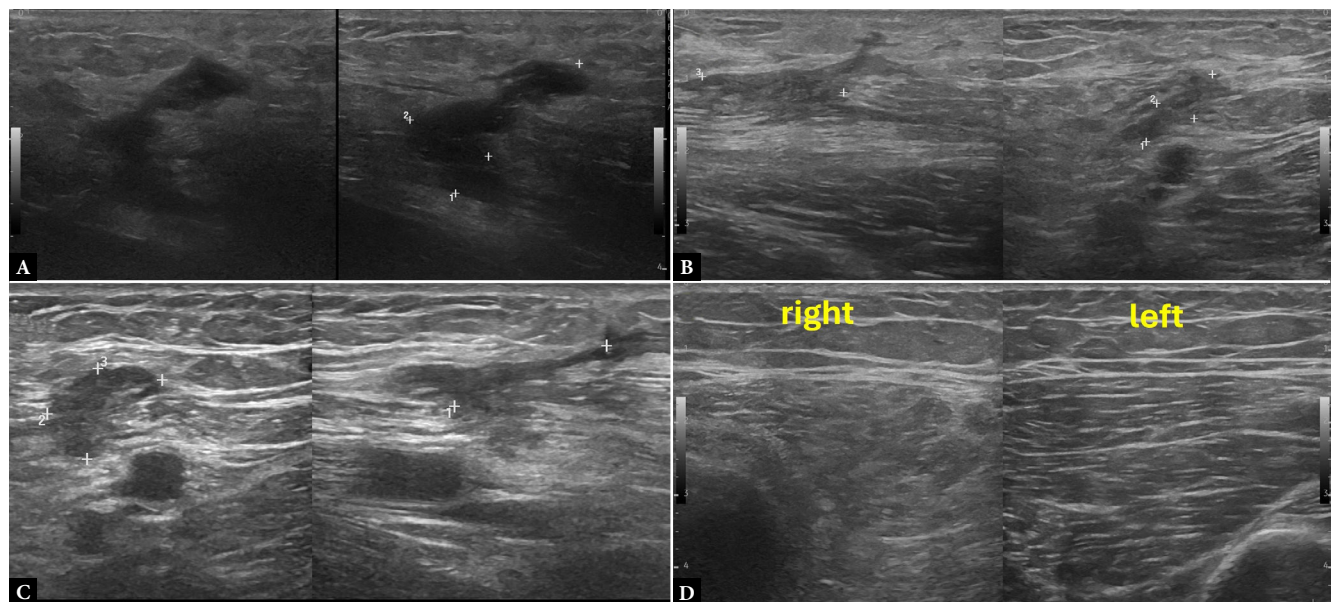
Ultrasound of the right rectus femoris muscle showing a heterogeneous hypoechoic lesion (1.2 × 1.6 × 2.7 cm) without internal flow on CD (A). Follow-up examinations at one (B) and four weeks (C) demonstrate progressive reduction in size (from 1.2 × 1.3 × 1 cm to 1.3 × 0.5 cm) and increasing echogenicity, consistent with resorptive hematoma evolution. Mild subcutaneous tissue edema persisted throughout the follow-up period. Comparative imaging (D) highlights muscle asymmetry and echotextural inhomogeneity, suggestive of evolving structural remodeling
